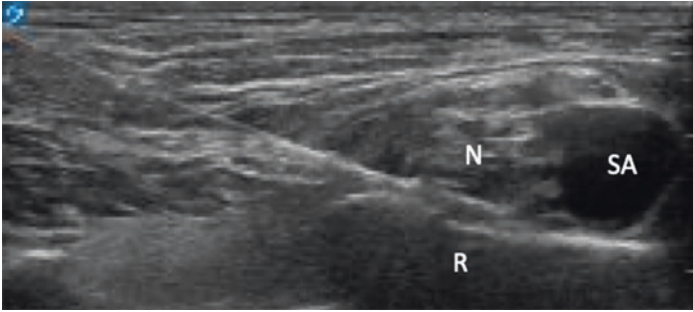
Supraclavicular block, ultrasound image. SA subclavian artery, N brachial plexus nerves, R rib
